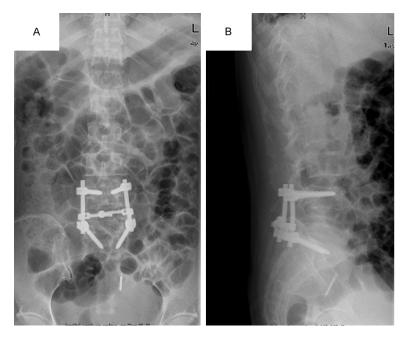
Post-operative lumbar anterior-posterior and lateral X-ray images. Post-operative lumbar anterior-posterior and lateral X-ray images (A: Anteroposterior view; B: Lateral view) showed the accurate positioning of the pedicle screws and rods without irritation of the spinal canal.
